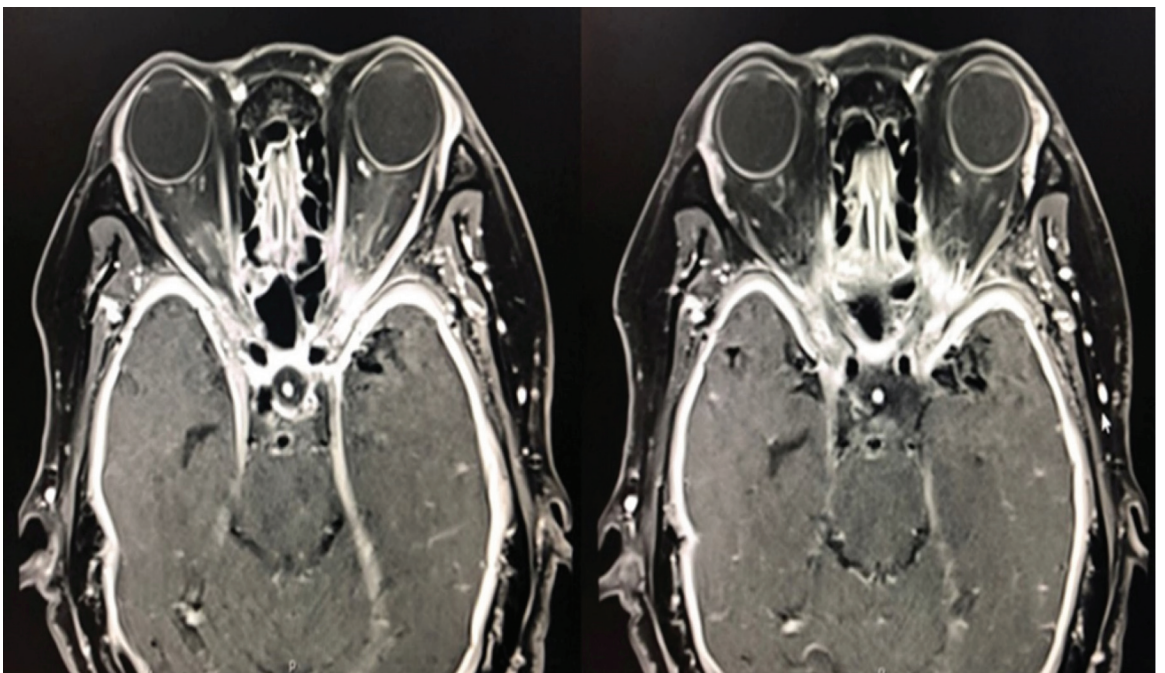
Contrast enhanced MRI brain and orbit revealed ill-defined infiltrative lesions at bilateral orbital apices, bilateral optic canals and bilateral Meckel's caves.
